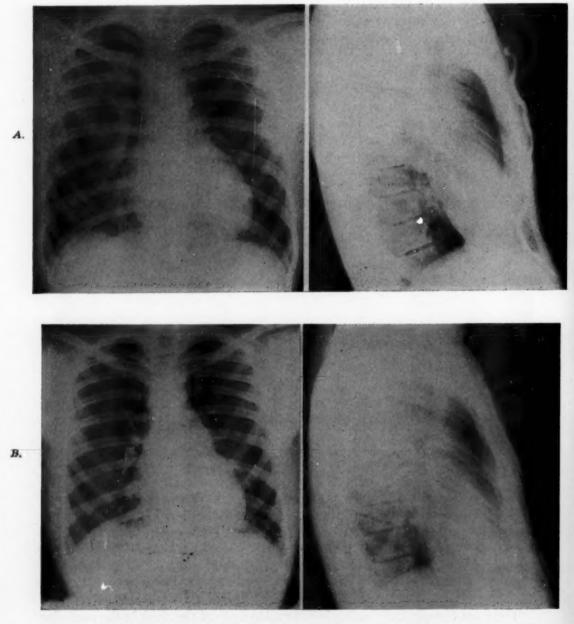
Patient F. B., 16-year-old boy. A, Preoperative radiographic examination of chest. The patient's funnel chest deformity was deep and particularly broad, extending almost to the midclavicular lines on each side. The posterior-anterior projection reveals a broadened cardiac silhouette. The lateral view demonstrates the extent of the chest deformity through a roll filled with barium paste attached to the patient's skin with adhesive tape. Note the small posterior-anterior diameter of heart and chest ("Pancake Heart").
